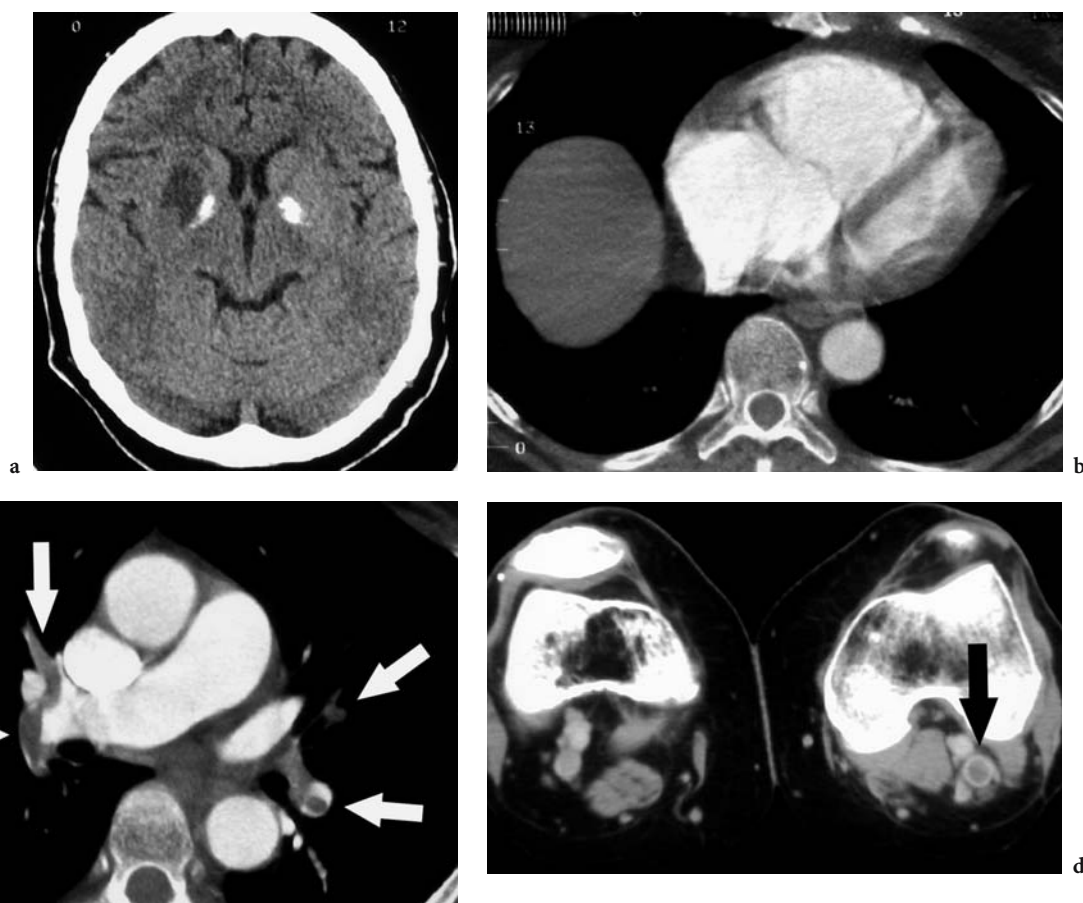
Paradoxical embolism. A 66-year-old woman presented with left hemiparesis. Echocardiography revealed right-to-left intracardiac shunt. a A CT of the brain demonstrated an ischaemic area in the right putamen. b, c Spiral CT of the thorax showed severe dilation of the right heart cavities. Multiple asymptomatic emboli were demonstrated in central and segmental pulmonary arteries (*arrows*). d CT venography showed segmental asymptomatic thrombosis of the left popliteal vein (*arrow*)
